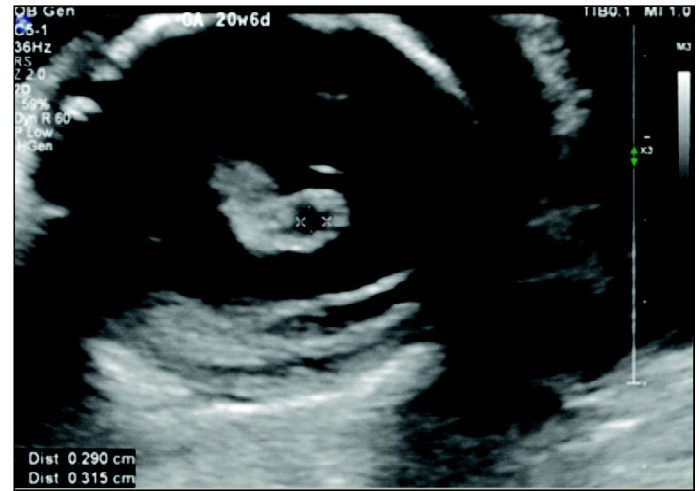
2 D gray scale ultrasound image of fetal brain showing a well-defined hypoechoic sub centimetric structure within the lateral ventricle of fetus, s/o choroid plexus cyst.
